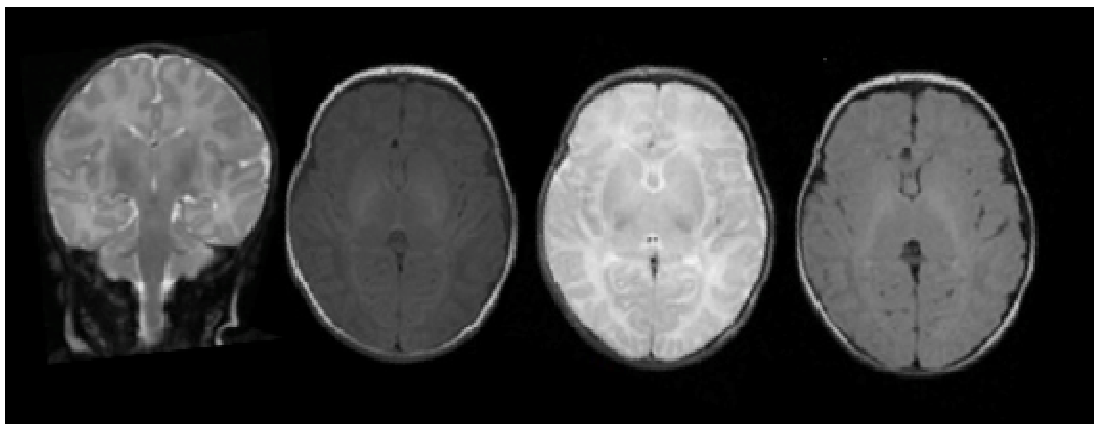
MR study: (a) coronal T2-FSE, (b) axial T1-SE, (c) axial HR T2 FAT SAT sequences and (d) axial FLAIR don't show any abnormalities in the brain
